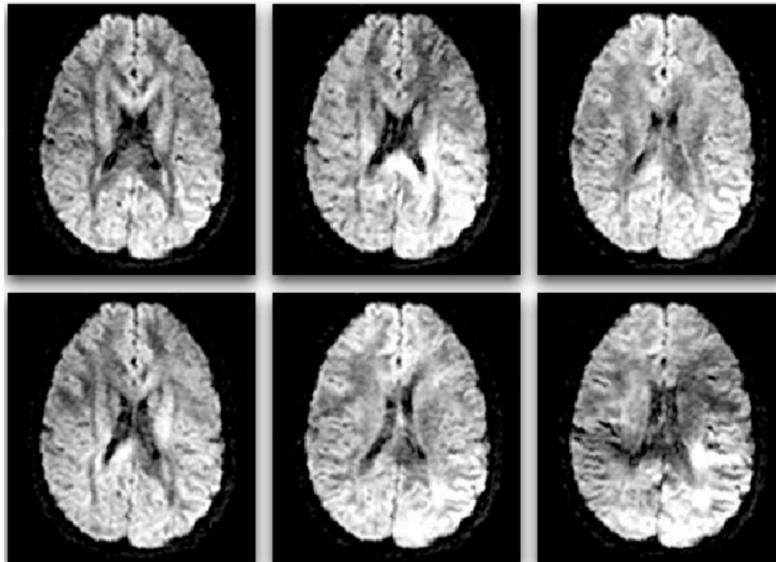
Six diffusion-weighted images (the minimum number required for tensor calculation). In diffusion MRI, magnetic field gradients are employed to sensitize the image to diffusion in a particular direction. The direction is different for each image, resulting in a different pattern of signal loss (dark areas) due to anisotropic diffusion. Reproduced with permission from (O'Donnell & Westin 2011).
